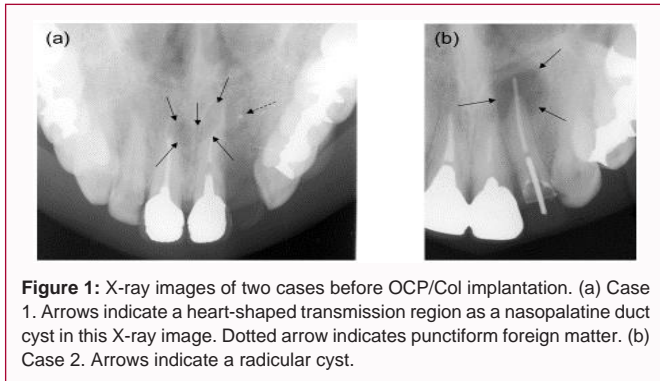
X-ray images of two cases before OCP/Col implantation. (a) Case 1. Arrows indicate a heart-shaped transmission region as a nasopalatine duct cyst in this X-ray image. Dotted arrow indicates punctiform foreign matter. (b) Case 2. Arrows indicate a radicular cyst.
